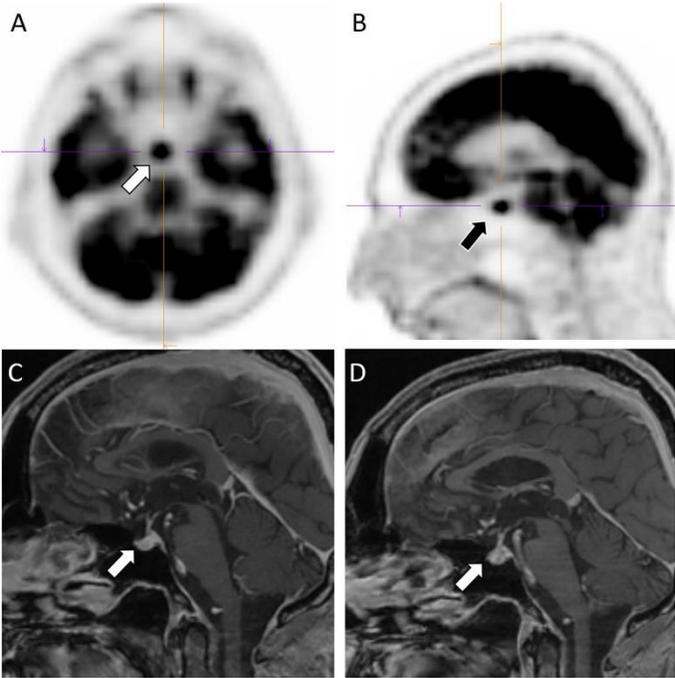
Selected transaxial and sagittal FDG PET (A and B) and sagittal MRI before and after treatment (C and D) show findings consistent with hypophysitis (arrows) (details in the text).
